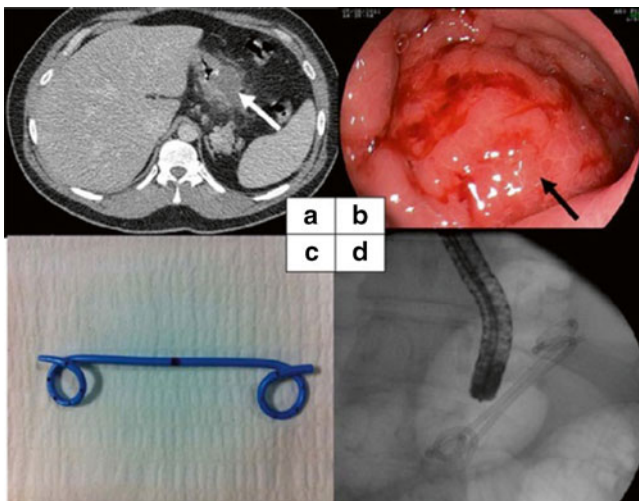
Delayed-onset gastric leak. (a) A fluid collection bulging in the stomach (*white arrow*). (b) Fluid collection bulging in the stomach (*black arrow*). (c) A pigtail drain. (d) Abdominal X-ray showing two pigtail drains after the endoscopic procedure. Reproduced with permission from *OBES SURG* 2012;22:712-720. Is There a Place for Pigtail Drains in the Management of Gastric Leaks After Laparoscopic Sleeve Gastrectomy?.
